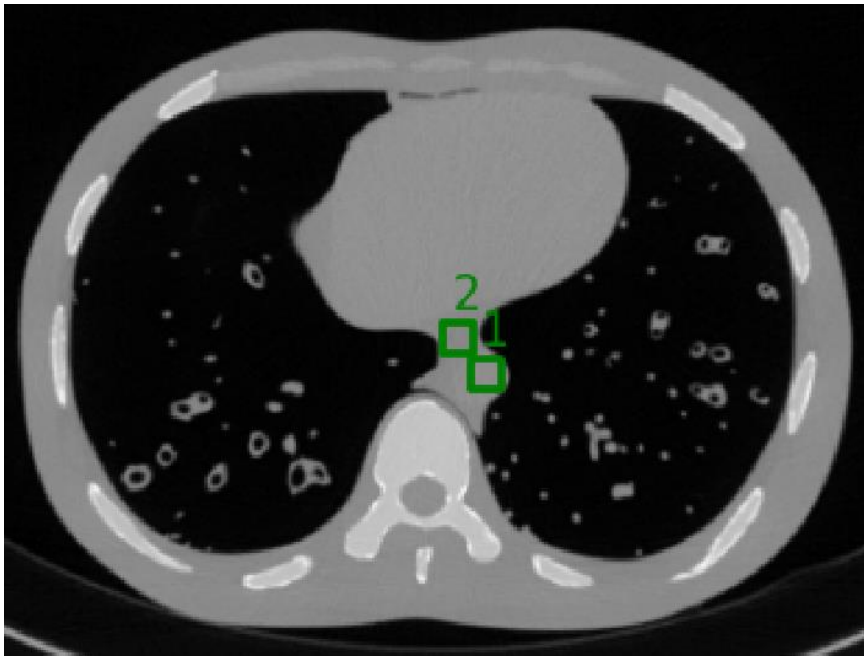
The chosen CT slice of the mediastinum and the position of the ROIs used to calculate the objective image quality parameters SNR and CNR.
